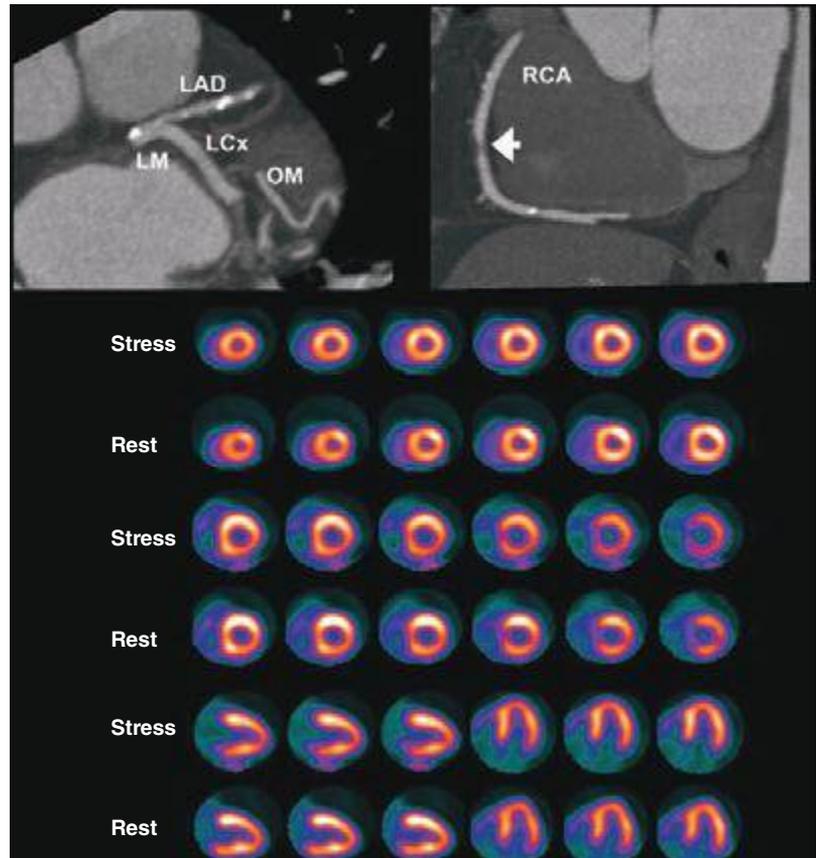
16 Selected views from coronary computed tomography angiographic (CTA) images (top panel) and stress and rest rubidium-82 myocardial perfusion positron emission tomography images (lower panel) obtained on a 64-year-old male patient with atypical angina. The CTA images demonstrate dense focal calcifications in the left main (LM) and left anterior descending (LAD) coronary arteries and a significant noncalcified plaque in the mid right coronary artery (RCA; arrow). The myocardial perfusion images demonstrated no evidence of flow-limiting stenosis. LCx, left circumflex artery; OM, obtuse marginal branch.
